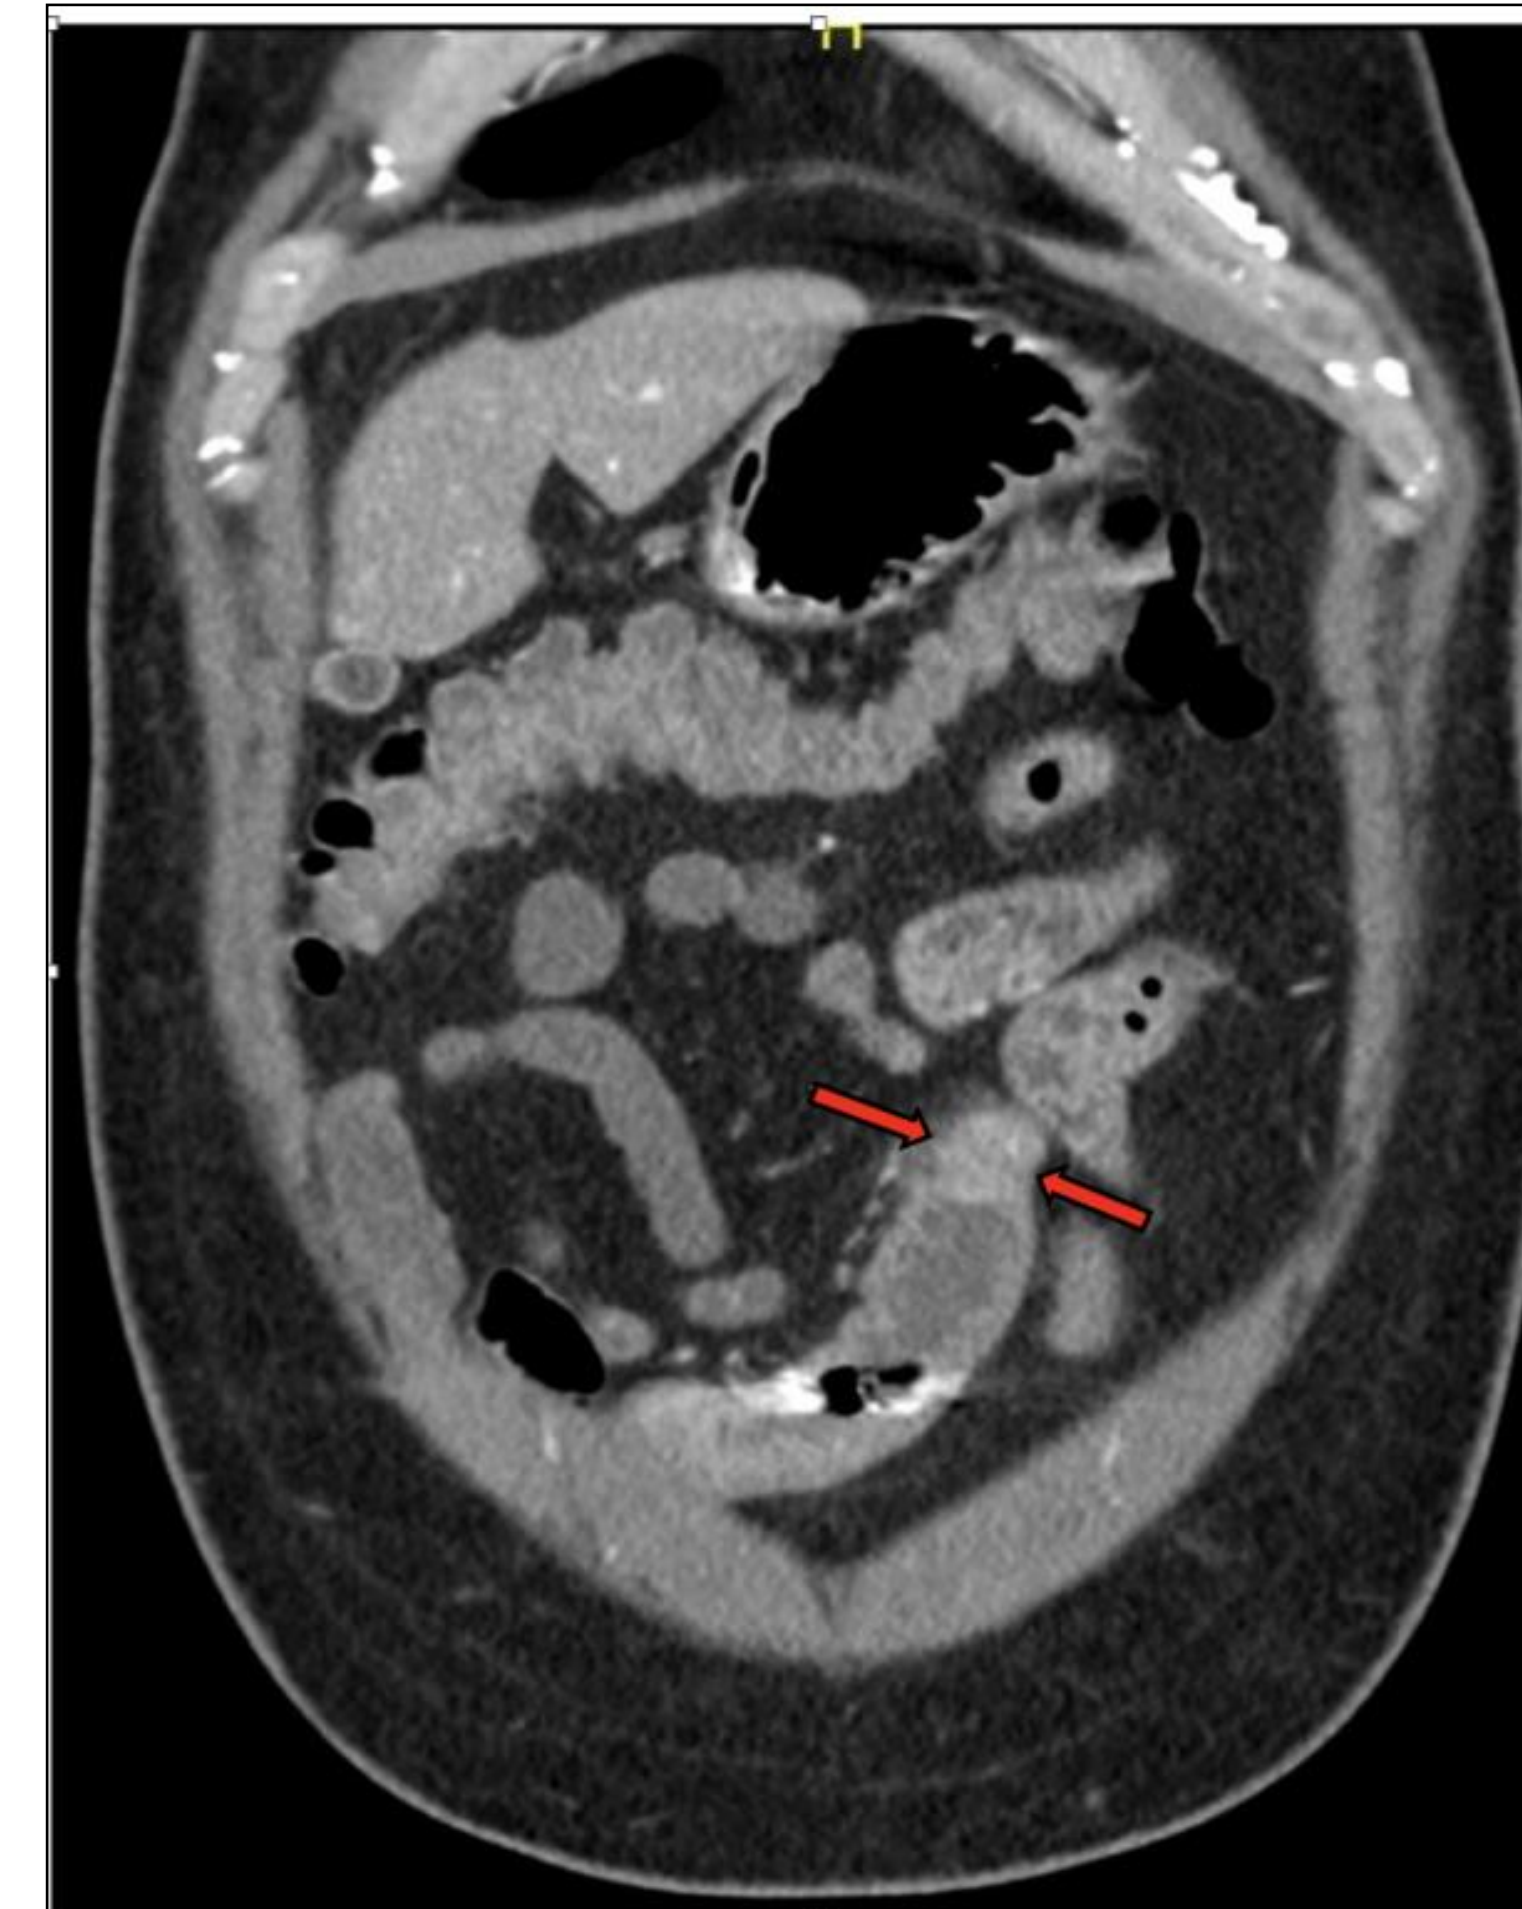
CT with positive oral contrast showing obstruction as indicated by the dilated loops of small bowel followed by collapsed bowel. Contrast material advanced past this point indicating the presence of partial obstruction.
